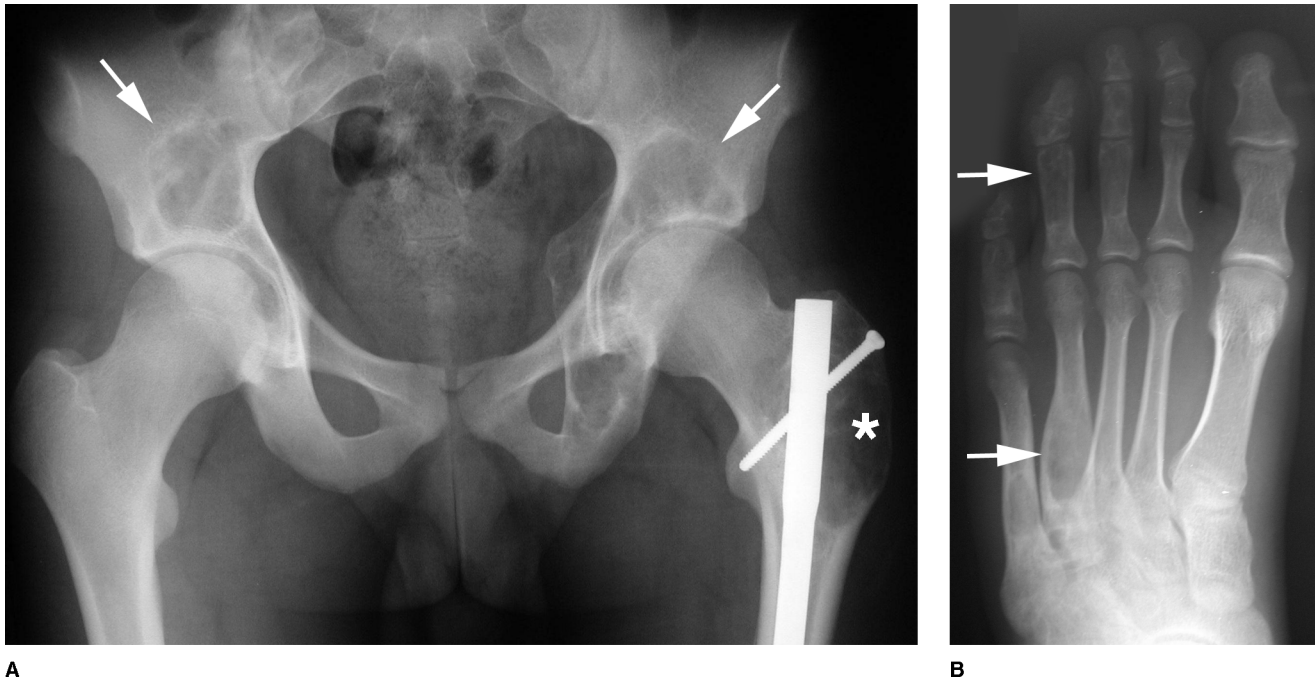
A, Anteroposterior radiograph showing polyostotic fibrous dysplasia affecting the pelvis (arrows) and the proximal femur (asterisk). B, Anteroposterior radiograph showing polyostotic disease of the foot (arrows). (Copyright © Rakesh Donthineni-Rao, MD.)
